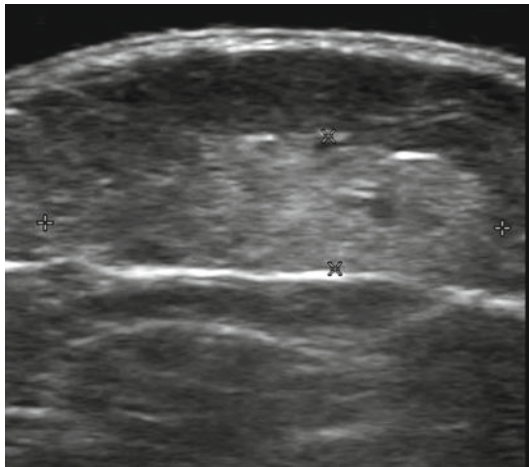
Gray scale sonographic grading of echogenicity during the different phases of hemangiomas
